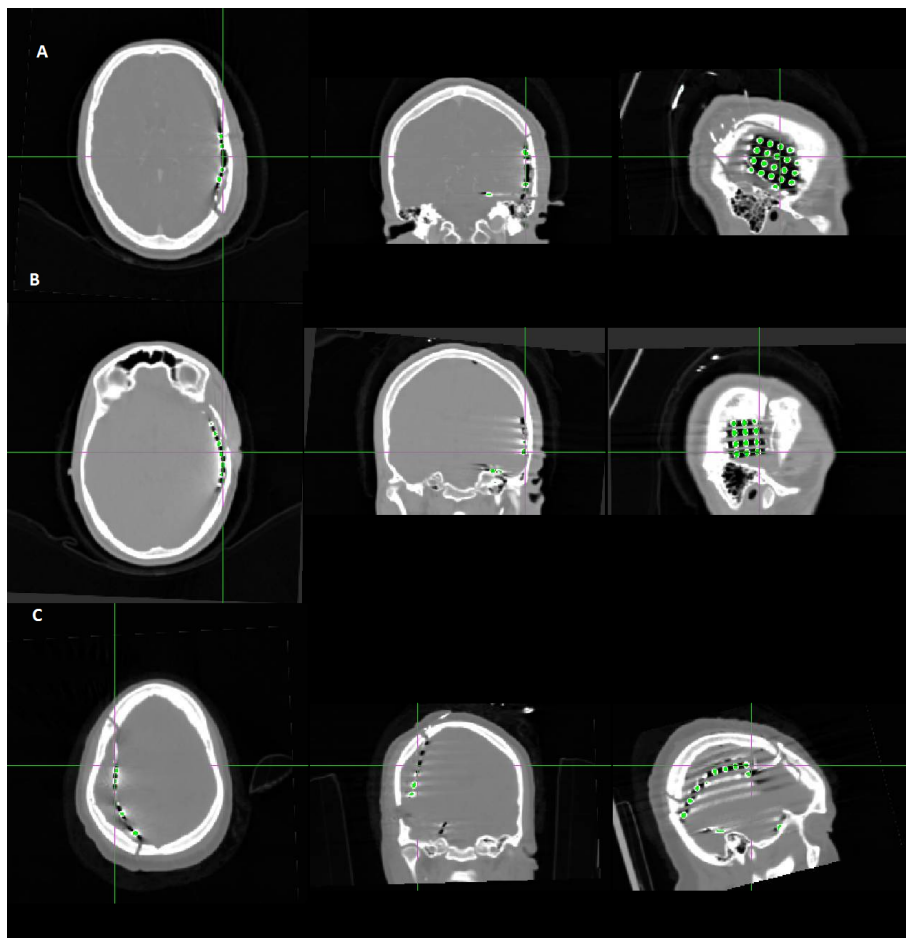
Fusion of CT dataset with CT mask, for (A) patient 1, (B) patient 2 and (C) patient 3 data.
